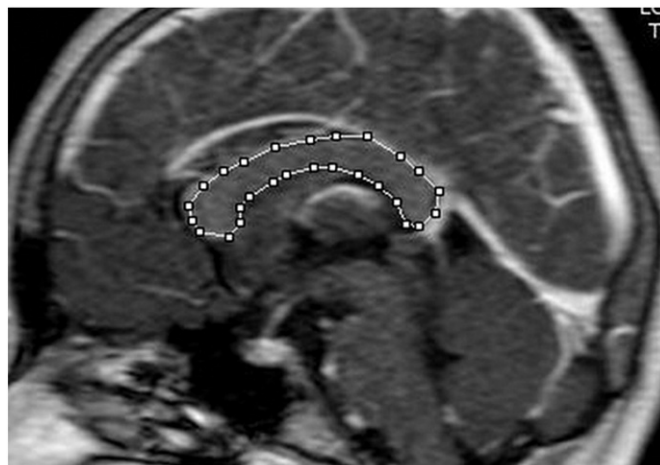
CC area. Midsagittal T1-weighted image demonstrates the midsagittal surface area measurement of CC.
